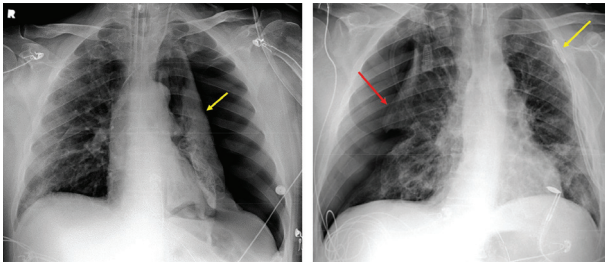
Frontal chest X-Ray scan confirming Barotrauma in 64-year-old male suffering from diabetes and hypertension, intubated for four days (a) Large left pneumothorax in lungs (yellow) 6 days after intubation. (b) A large right pneumothorax (red) developed 14 days later i.e., 20 days after intubation. The Radiograph highlights left pleural pigtail catheter (yellow) and re-expansion of left lung [21].
